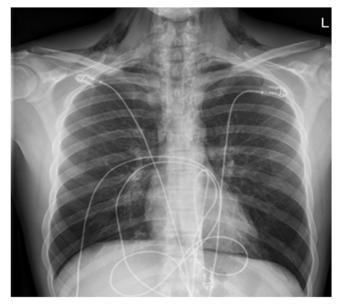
Chest x-ray, where the subcutaneous emphysema radiologically was also confirmed.
